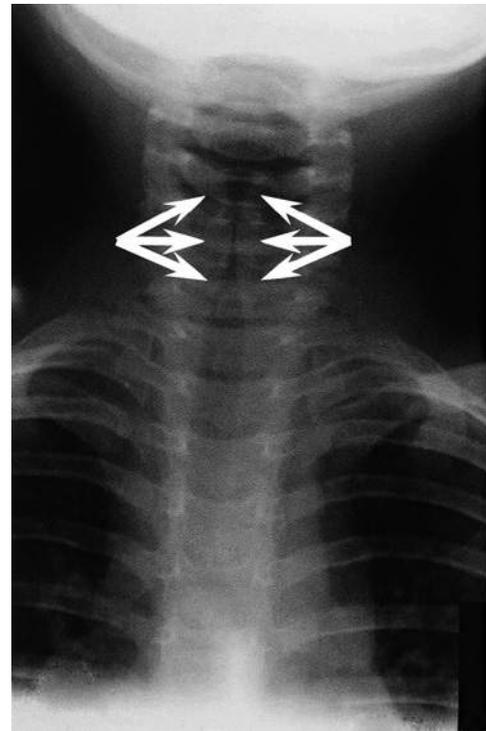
Anteroposterior chest radiograph of a patient with croup. Subglottic narrowing typical of croup is evident (arrows).
